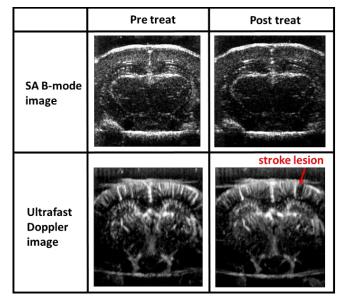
Synthetic aperture B-mode and ultrafast Doppler vasculature images before and after PT treatment.
